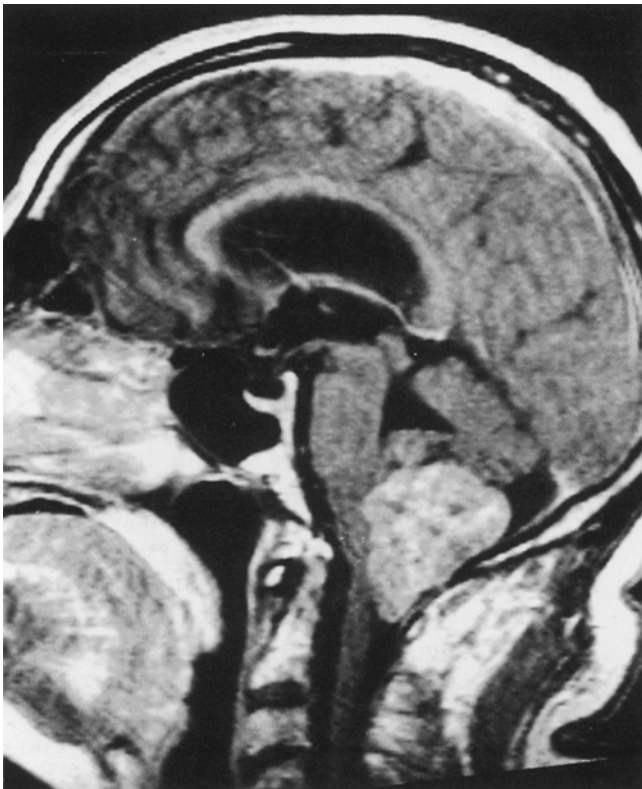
Sagittal T1-weighted MRI with gadolinium showing a large enhancing posterior fossa tumor which has involved the herniated cerebellar tonsils
